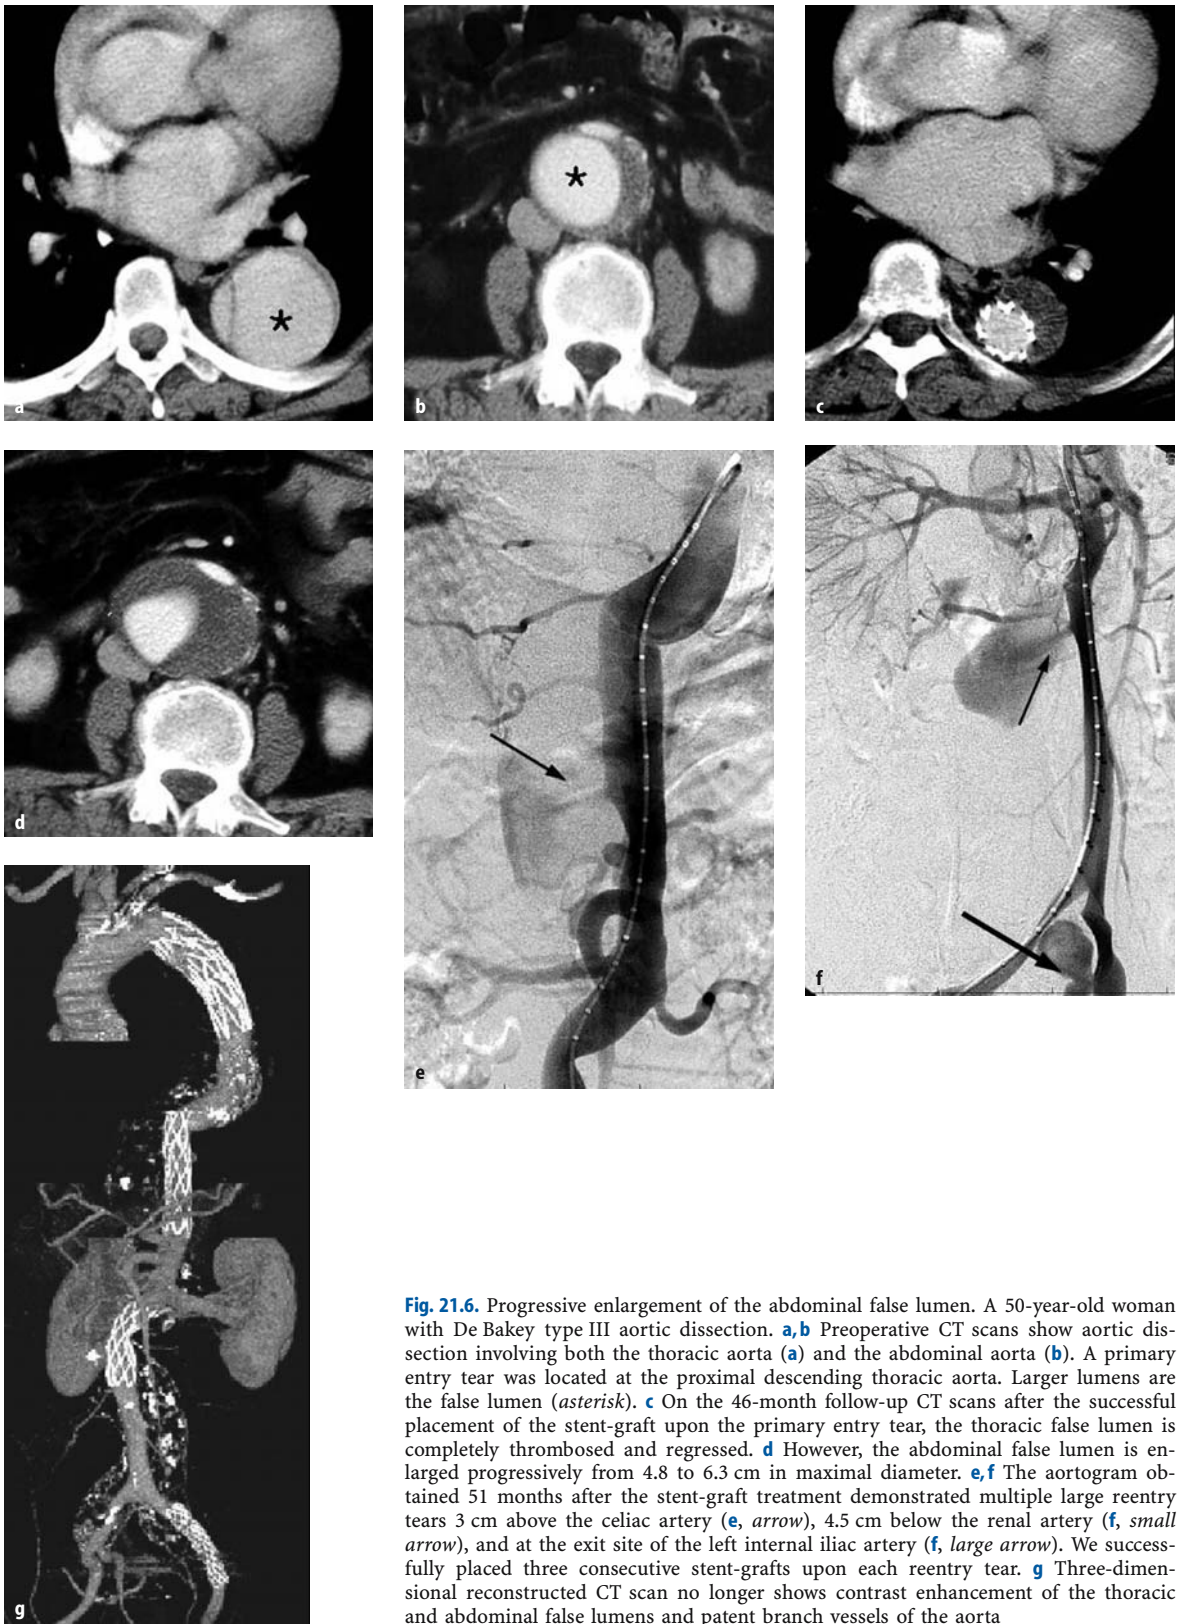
Progressive enlargement of the abdominal false lumen. A 50-year-old woman with De Bakey type III aortic dissection. a,b Preoperative CT scans show aortic dissection involving both the thoracic aorta (a) and the abdominal aorta (b). A primary entry tear was located at the proximal descending thoracic aorta. Larger lumens are the false lumen (*asterisk*). c On the 46-month follow-up CT scans after the successful placement of the stent-graft upon the primary entry tear, the thoracic false lumen is completely thrombosed and regressed. d However, the abdominal false lumen is enlarged progressively from 4.8 to 6.3 cm in maximal diameter. e,f The aortogram obtained 51 months after the stent-graft treatment demonstrated multiple large reentry tears 3 cm above the celiac artery (e, *arrow*), 4.5 cm below the renal artery (f, *small arrow*), and at the exit site of the left internal iliac artery (f, *large arrow*). We successfully placed three consecutive stent-grafts upon each reentry tear. g Three-dimensional reconstructed CT scan no longer shows contrast enhancement of the thoracic and abdominal false lumens and patent branch vessels of the aorta
